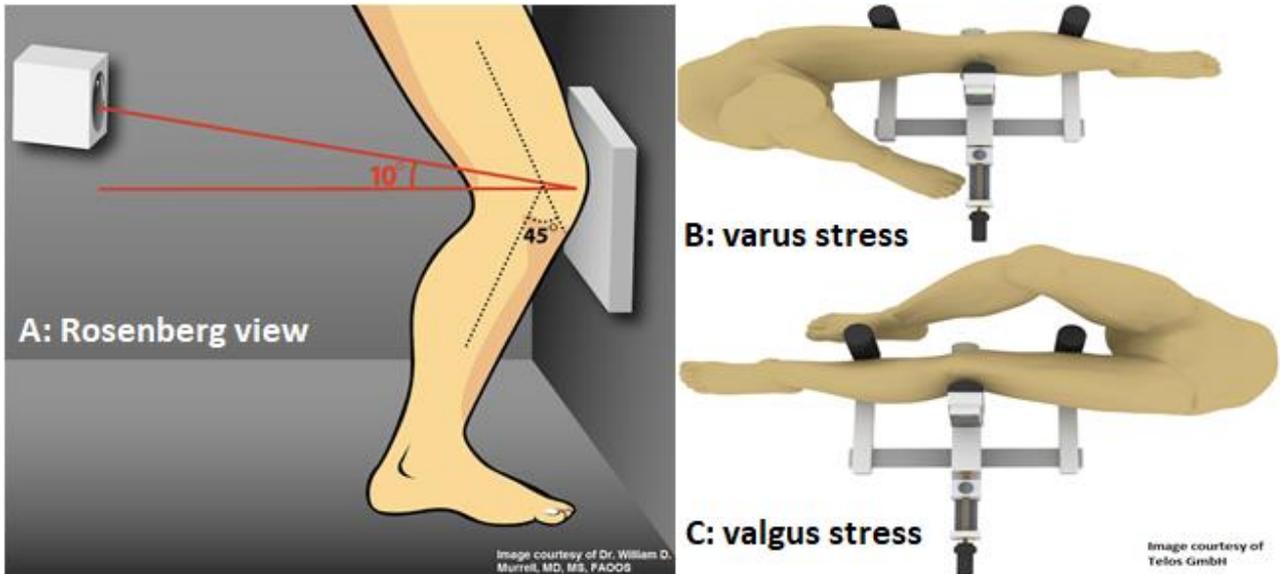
Method of Rosenberg (A), Telos Varus stress (B), and Valgus stress radiography (C).
